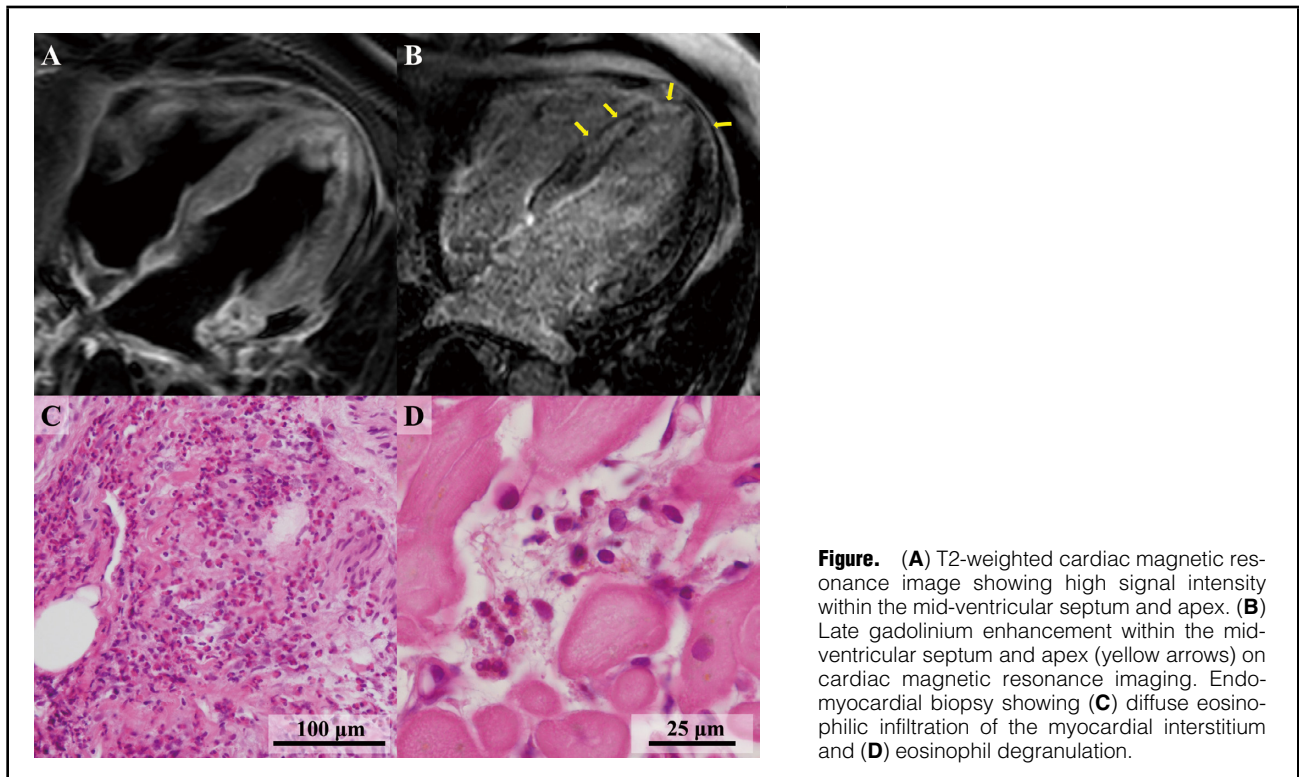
(A) T2-weighted cardiac magnetic resonance image showing high signal intensity within the mid-ventricular septum and apex. (B) Late gadolinium enhancement within the mid-ventricular septum and apex (yellow arrows) on cardiac magnetic resonance imaging. Endomyocardial biopsy showing (C) diffuse eosinophilic infiltration of the myocardial interstitium and (D) eosinophil degranulation.
